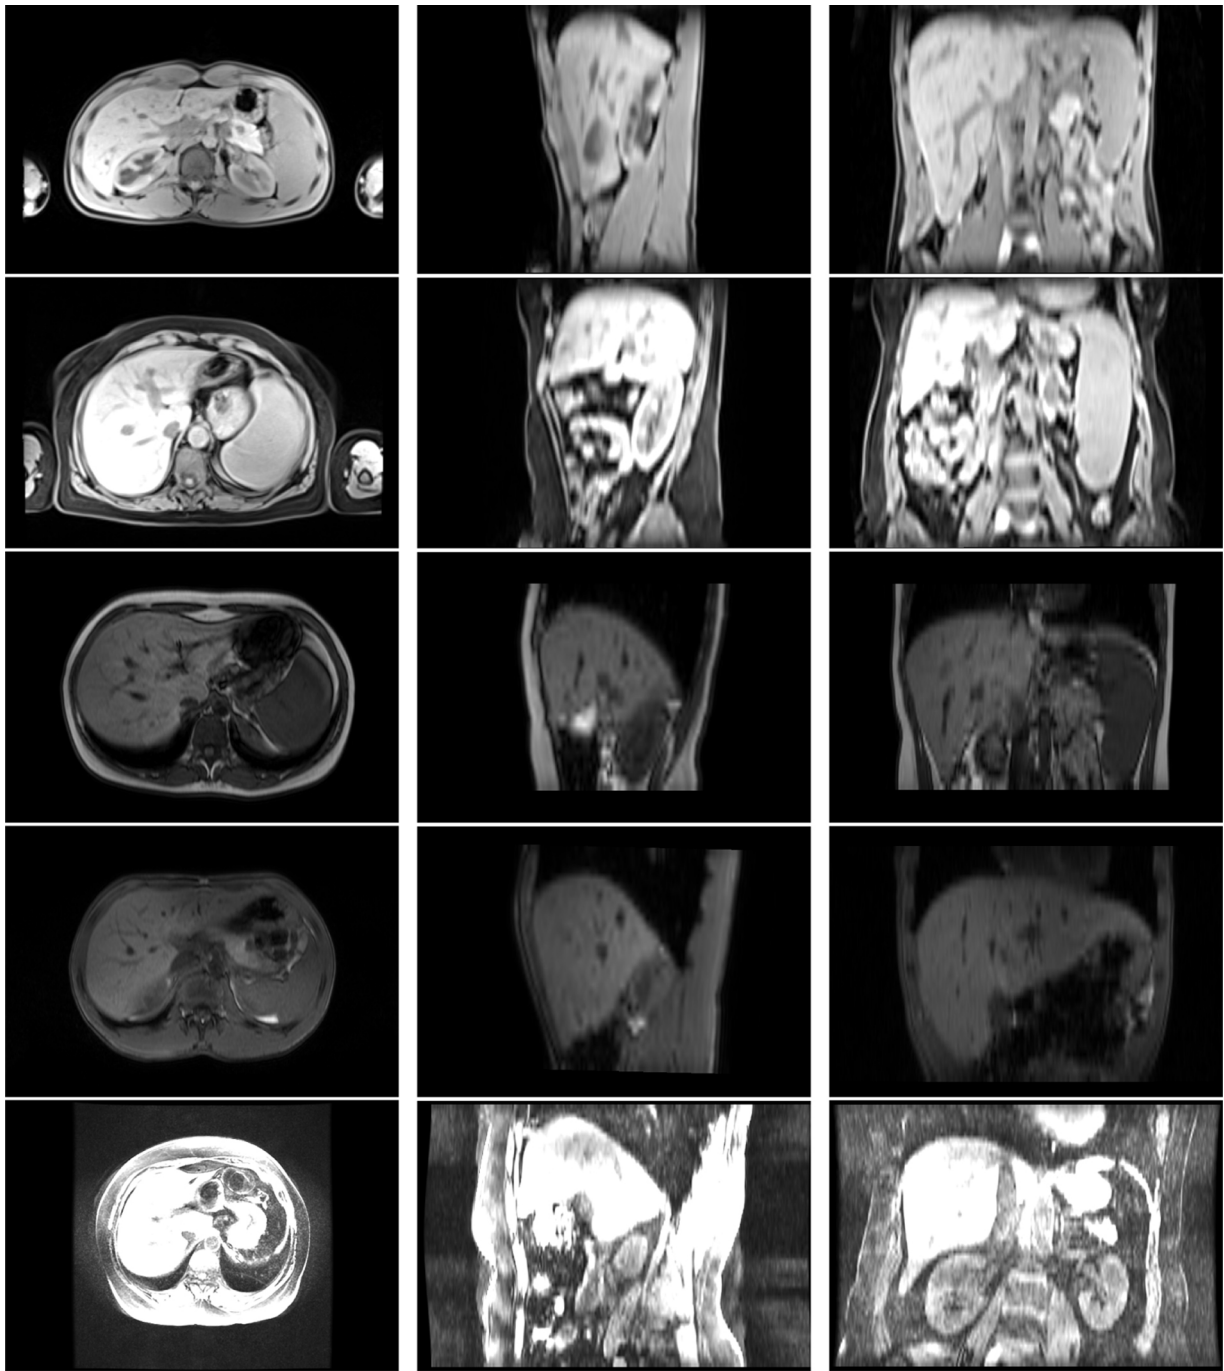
MR images in a FLD clinical trial. Each row is one subject in axial, sagittal and coronal views.
